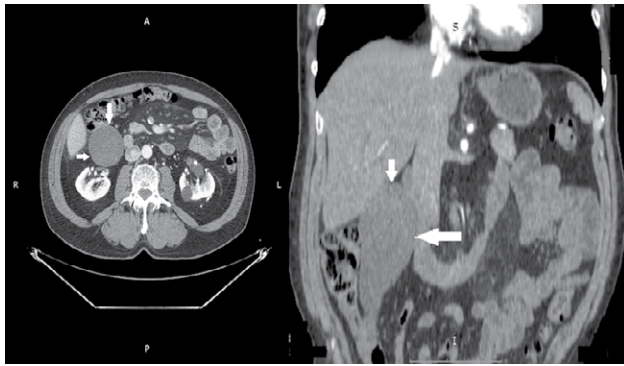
Spiral CT picture of abdominal organs with contrast (arrows indicate a pathological formation)
